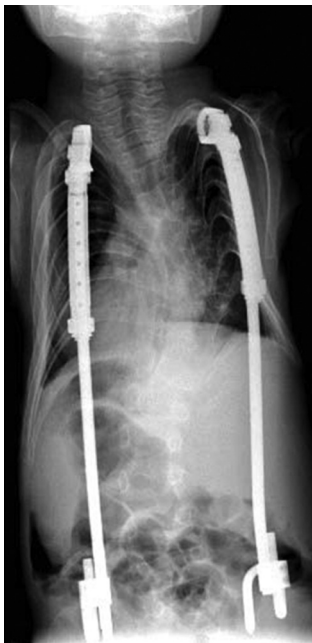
Anteroposterior scoliosis X-ray immediately after initial non-coated Vertical Expandable Prosthetic Titanium Rib placement.
